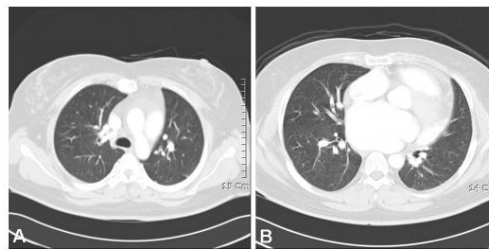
Follow-up chest CT eight days after management shows the findings of pulmonary hemorrhage completely resolve. (A : upper and mid lobe of lung, B : mid and lower lobe of lung)
